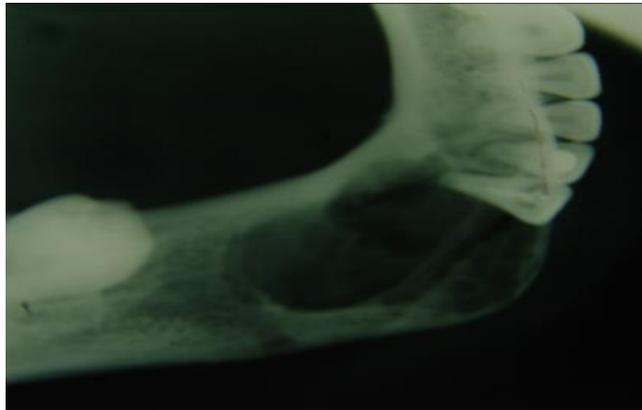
c.- Occlusal radiography shows a radiolucent shadow that compromises the left hemimaxilla.
